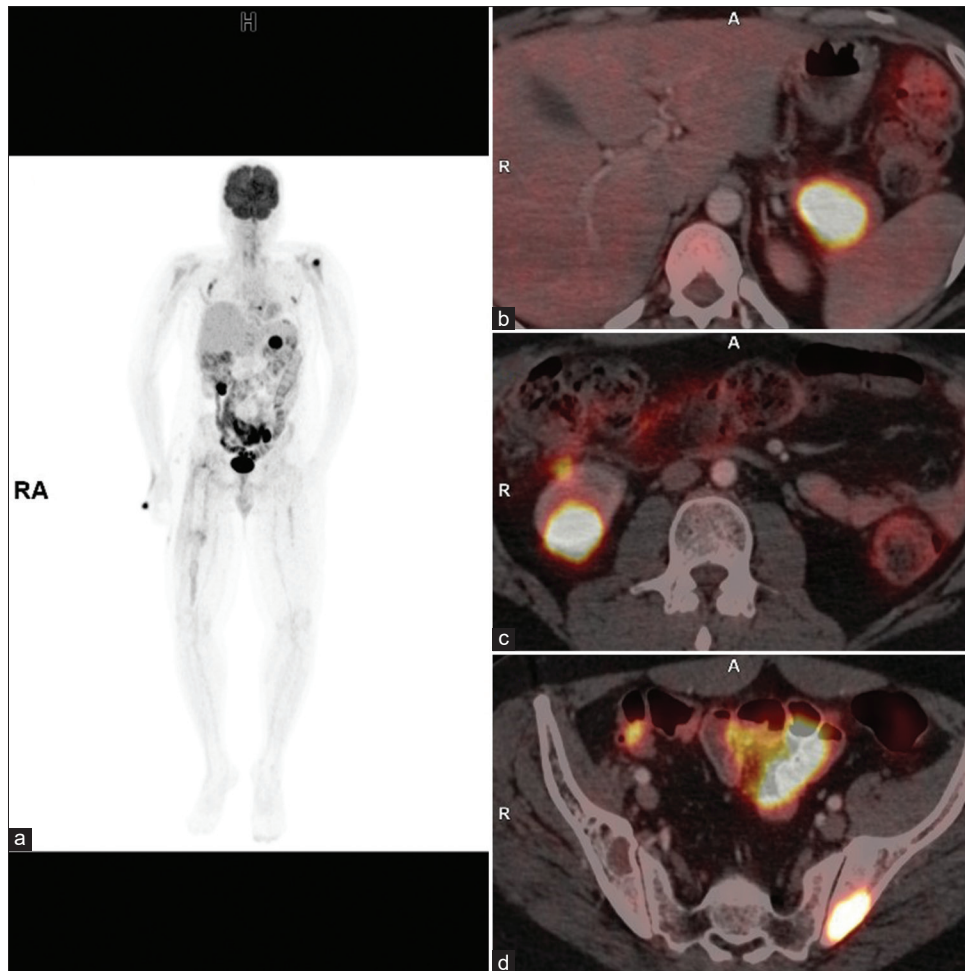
Whole-body MIP (a) axial fused  $^{18}\text{F}$ -FDG PET/CT image showing pancreatic lesion (b) right kidney lesion (c), and right iliac bone lesion (d). MIP: Maximum intensity projection,  $^{18}\text{F}$ -FDG PET/CT:  $^{18}\text{F}$ -fluorodeoxyglucose positron emission tomography/computed tomography
